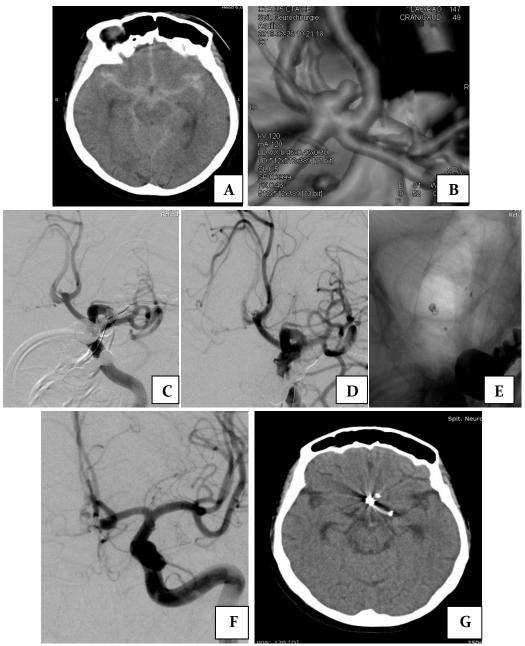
A – Diagnosis CT scan showing SAH; B – 3D reconstruction of CTA; C- Diagnosis DSA; D – DSA control after first coil deployment; E – Fluoroscopy for stent complete deployment control; F – Control DSA after complete aneurysm coil occlusion; G – Postoperative CT scan control
